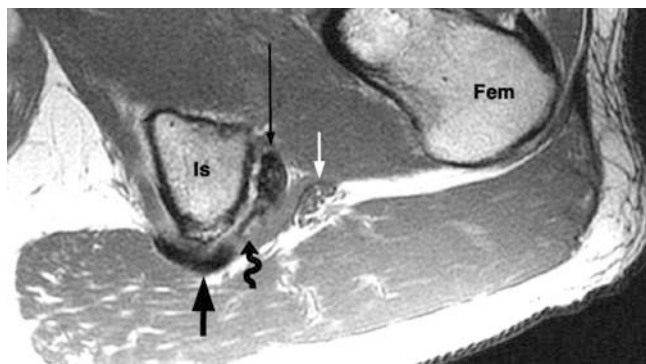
High-grade tear of hamstring tendon in 51-year-old squash player with increasing pain. Axial proton density-weighted MR image shows semimembranosus tendon (*thin straight black arrow*), sacrotuberous ligament (STL) (*thick straight black arrow*) and sciatic nerve (*white arrow*) at level of ischial tuberosity (Is) and proximal femur (Fem). In expected location of semitendinosus-biceps femoris (ST-BF), ossific focus (*wavy black arrow*) indicates chronic tendinopathy and high-grade tear. Tendon retraction was limited because the STL remained continuous with ST-BF (not shown)
